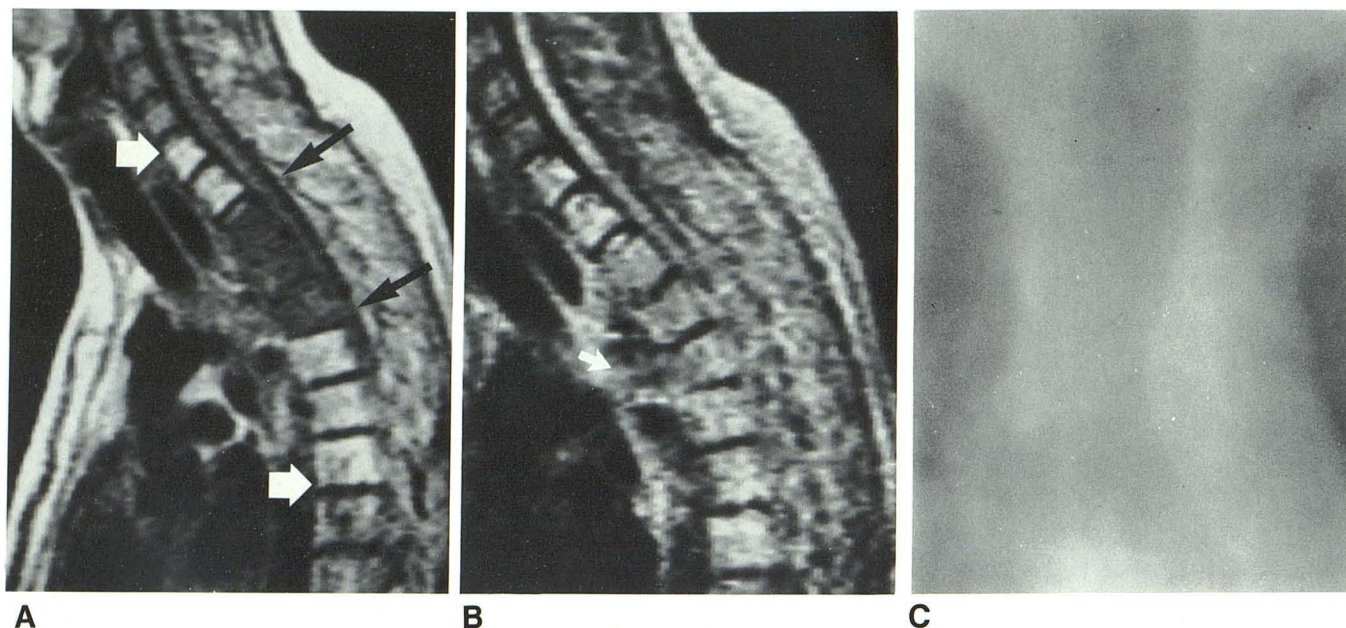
Case 1. A, SE 530/30 image using two signal averages per slice. Area of increased signal intensity involves C7, T1, and T5–T7 (white arrows). T2–T4 vertebral bodies demonstrate low signal intensity secondary to tumor involvement (black arrows). B, SE 2090/90 or T2-weighted image shows pathologic fracture of anterior part of T3 and T4 better. Also, large anterior paraspinal soft-tissue mass is at T3 level (arrow). Esophagus was invaded by
